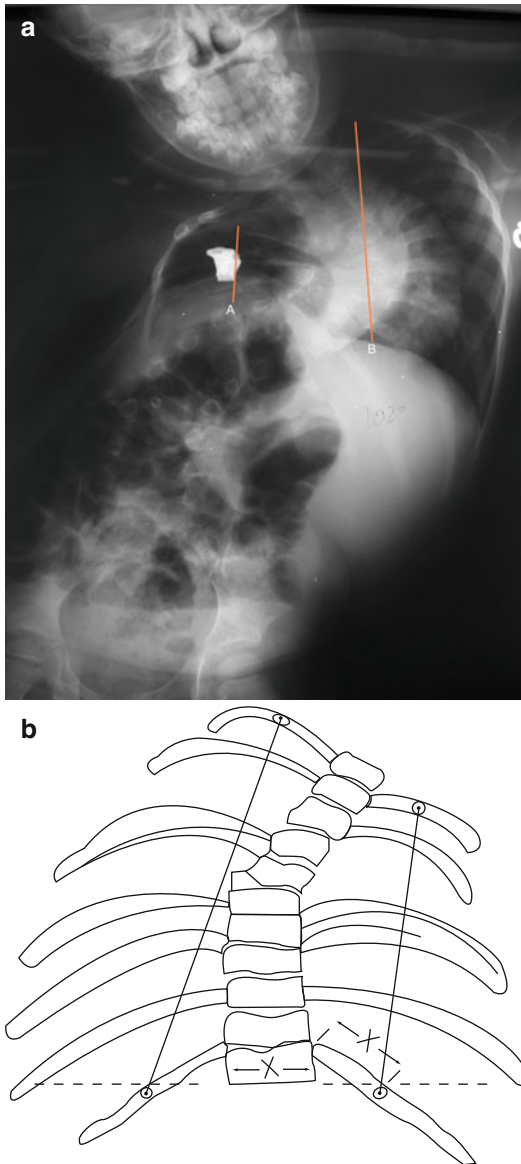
(a) Space available for the lung (SAL). This is a ratio that documents the effect of the three-dimensional deformity of the chest on potential lung growth. (b) Space available for the lung (SAL). The SAL is a ratio expressed as a percentage of the distance from the diaphragm to the apex of the lung (A/B) measured on an upright radiograph of the chest when comparing one side to the other. In this example, the SAL is 70 % when comparing the right to the left
